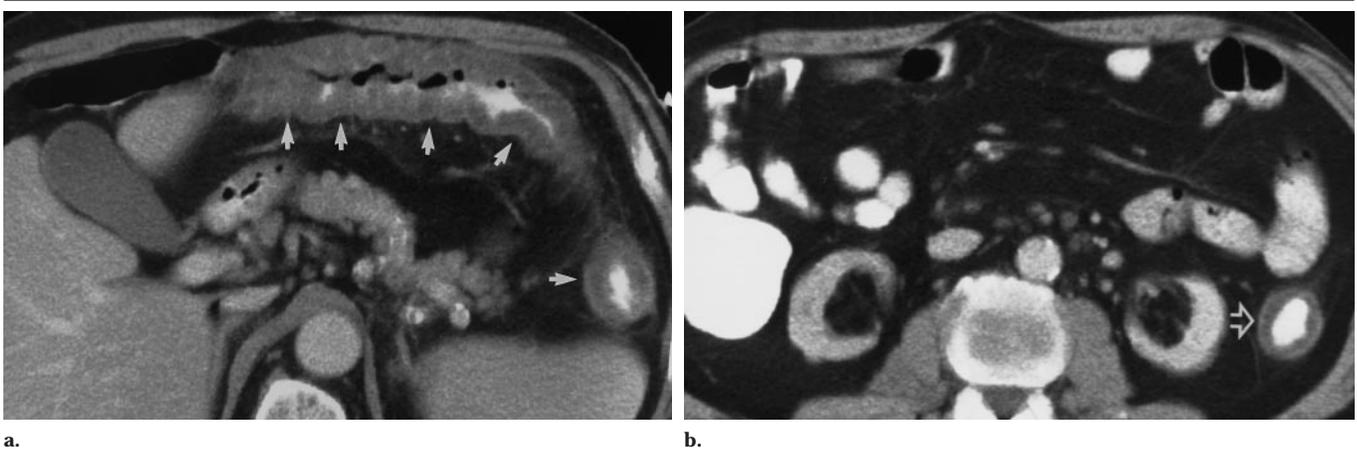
Ischemic colitis in a 47-year-old man with vasculitis, who presented with abdominal pain and bloody diarrhea. (a) Contrast-enhanced CT scan reveals involvement of the distal transverse colon and splenic flexure (arrows), with marked wall thickening and pericolic streakiness. (b) CT scan shows proximal descending colon with concentric layers of low and high attenuation (double-halo sign) (arrow), consistent with colonic edema. Diagnosis was confirmed at colonoscopy and biopsy. The ischemic process resolved; however, the patient returned 2 months later and died of extensive bowel infarction.
